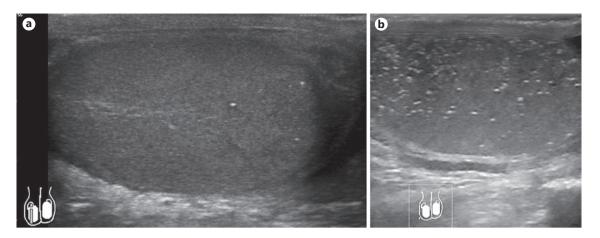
Ultrasound imaging of TML of infertile patients. a TML <5 microliths/transducer field. b TML ≥5 microliths/transducer field. TML, testicular microlithiasis.
